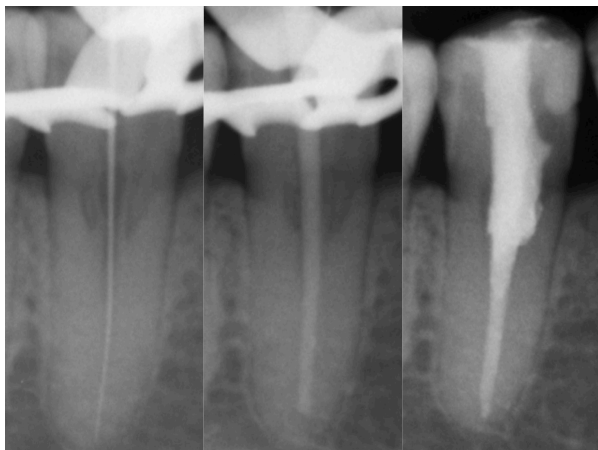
Treatment radiographs 45: same as fig. 13-4
